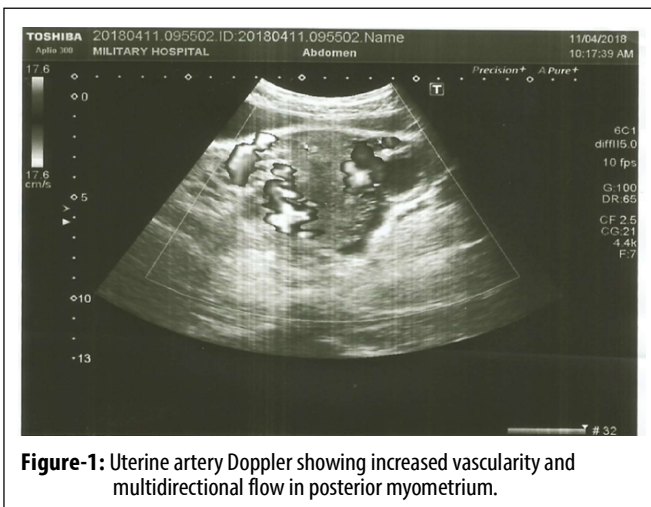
Uterine artery Doppler showing increased vascularity and multidirectional flow in posterior myometrium.
